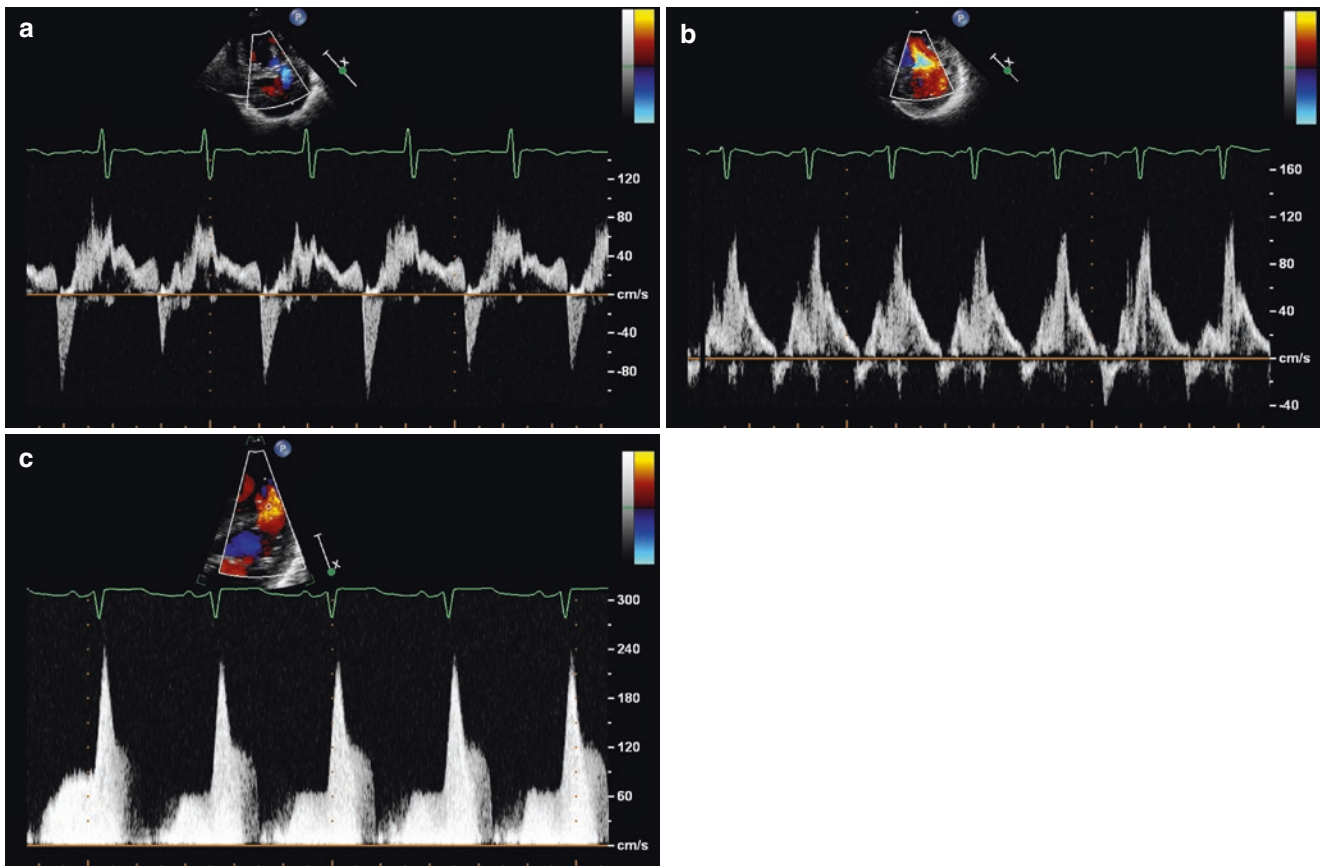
Pulsed wave Doppler of a large muscular VSD (parasternal short axis) in a neonate shows bidirectional shunting at low flow velocities (a); with decreasing pulmonary vascular resistance, shunting pattern changes into predominant (b) and later into exclusive LR-shunting (c)
